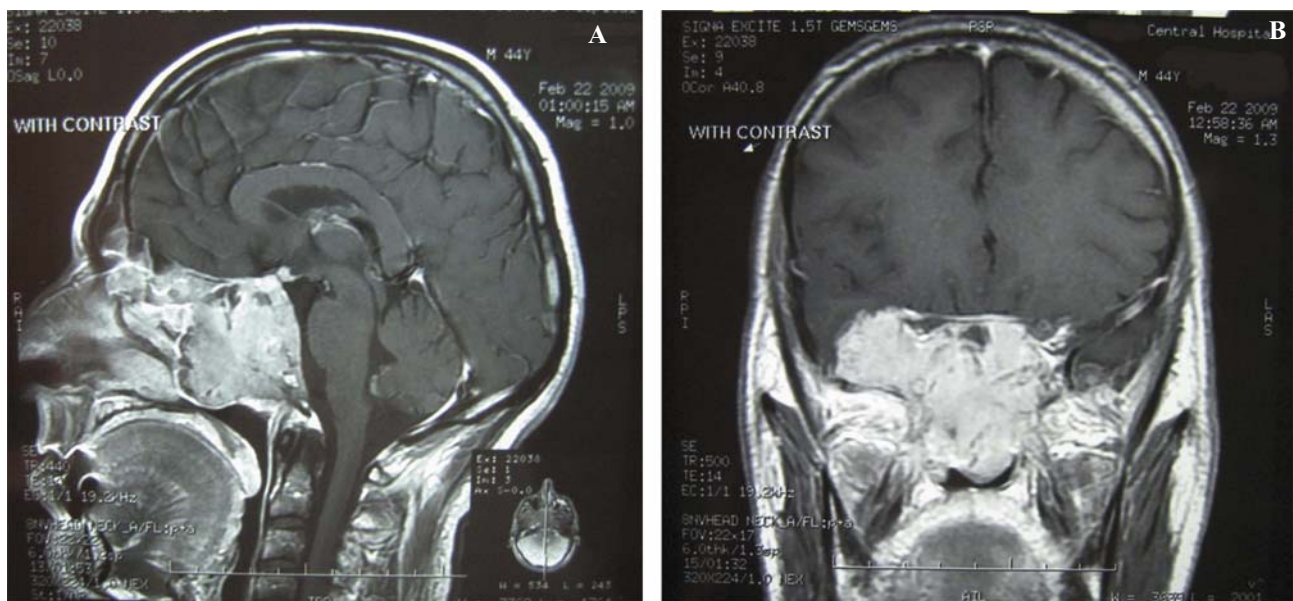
Contrast-enhanced sagittal (A) and coronal (B) view of T1-weighted MRI of the nasopharynx and skull base showing locally advanced nasopharyngeal adenoid cystic carcinoma invading the skull base, sphenoid sinus, sinuous cavernous, with extension to the intracranial fossa. (Case 5)
